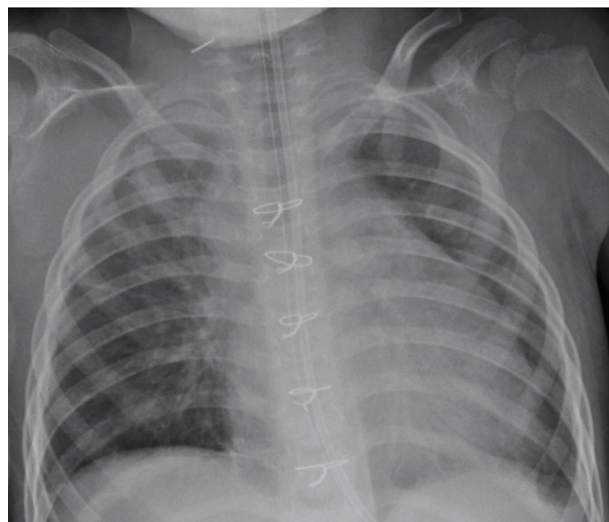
Case 1: Portable anteroposterior chest x-ray demonstrating improved right lung aeration with mild patchy volume loss in the right upper lobe.
